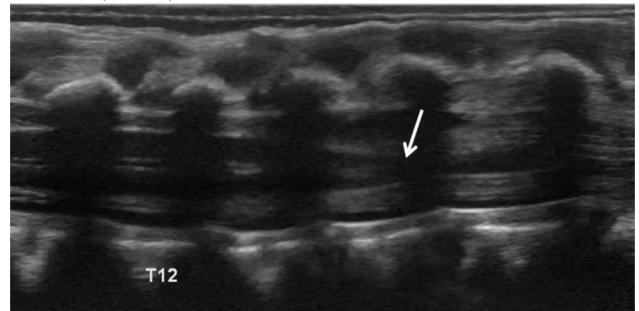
Sagittal ultrasound image of the lumbar spine demonstrating a normal shape and position of the conus medullaris at L2 (white arrow).
